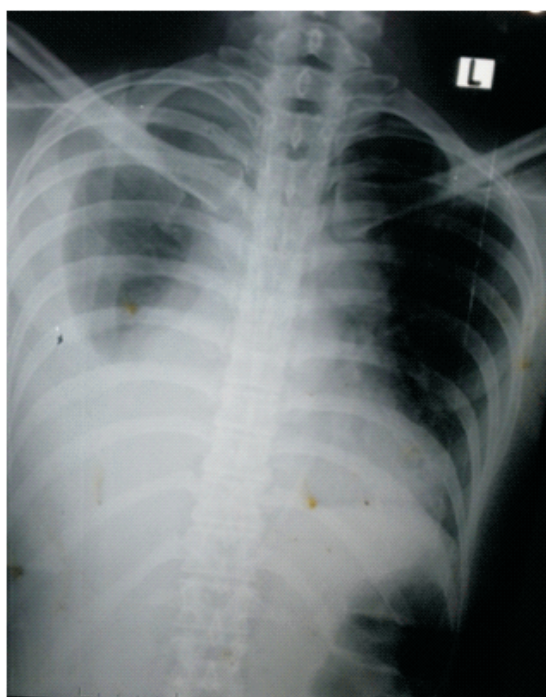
Chest radiograph showing right sided moderate pleural effusion with wide mediastinum
